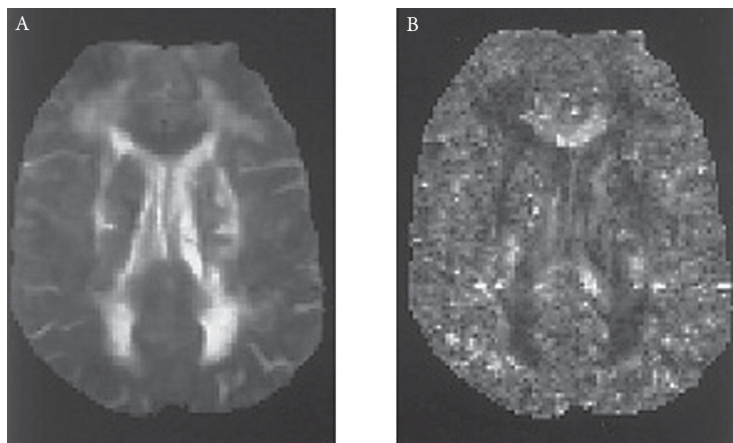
(A, B) Typical T2-weighted (A) and fractional anisotropy (B) images obtained from a patient. (A) The T2-weighted image shows regions of increased signal intensity adjacent to the horns of the lateral ventricles. (B) The fractional anisotropy image reveals a substantial loss of anisotropy in the regions of leukoaraiosis. (Adapted with permission from Jones DK. *Stroke*. 1999;30:393–397.).
